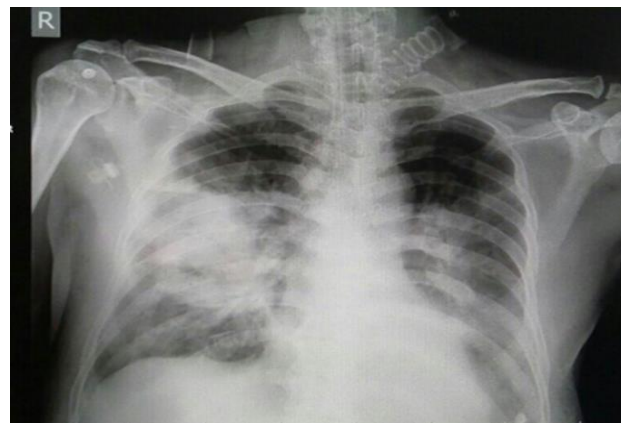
Chest X-ray showing consolidation of the right middle lobe.
